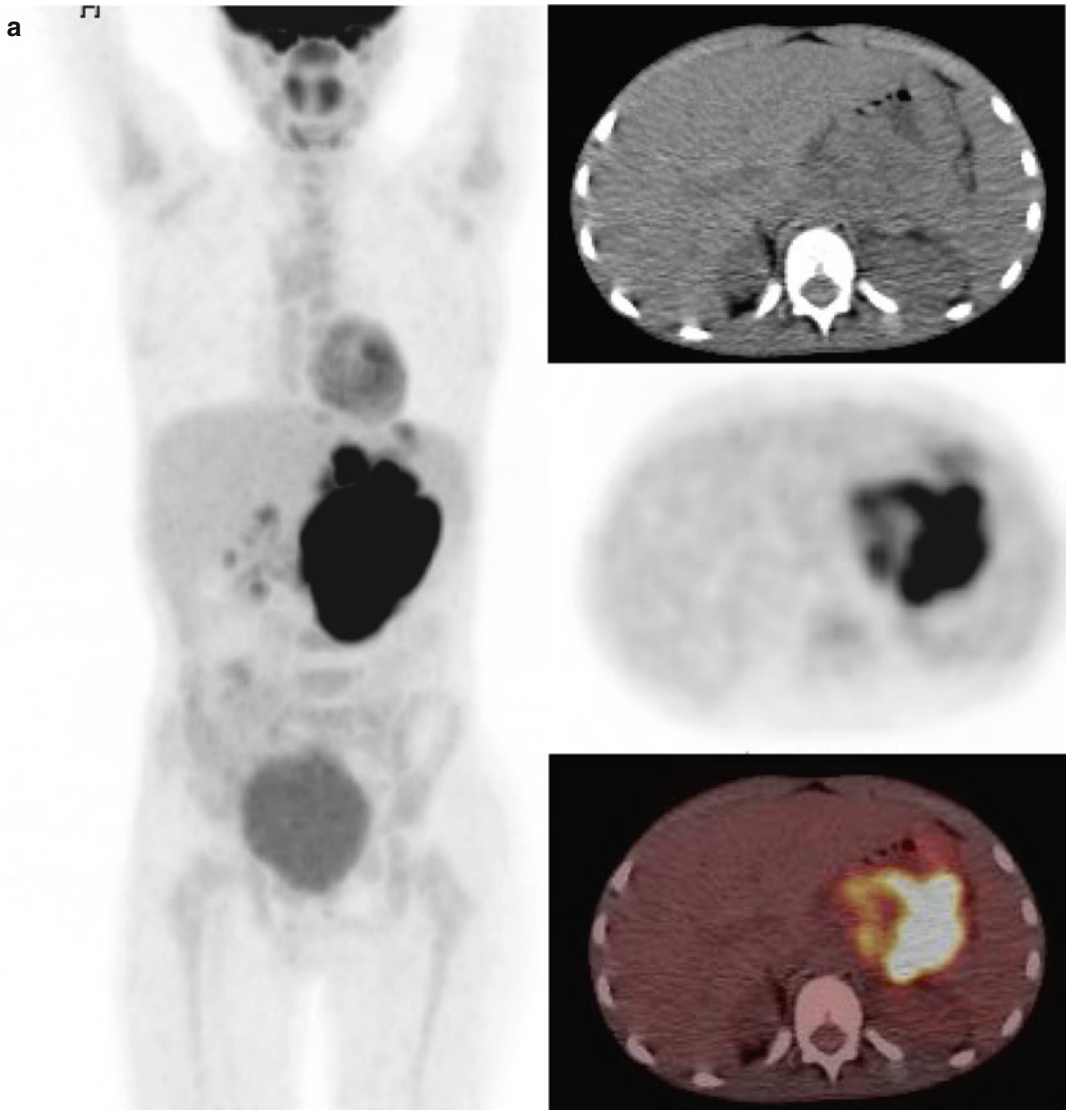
A 9-year-old boy with Burkitt lymphoma. Initial staging evaluation with PET/CT (coronal PET images (a left) and transverse CT, PET, and fused images (a right)) demonstrates markedly increased tracer activity
